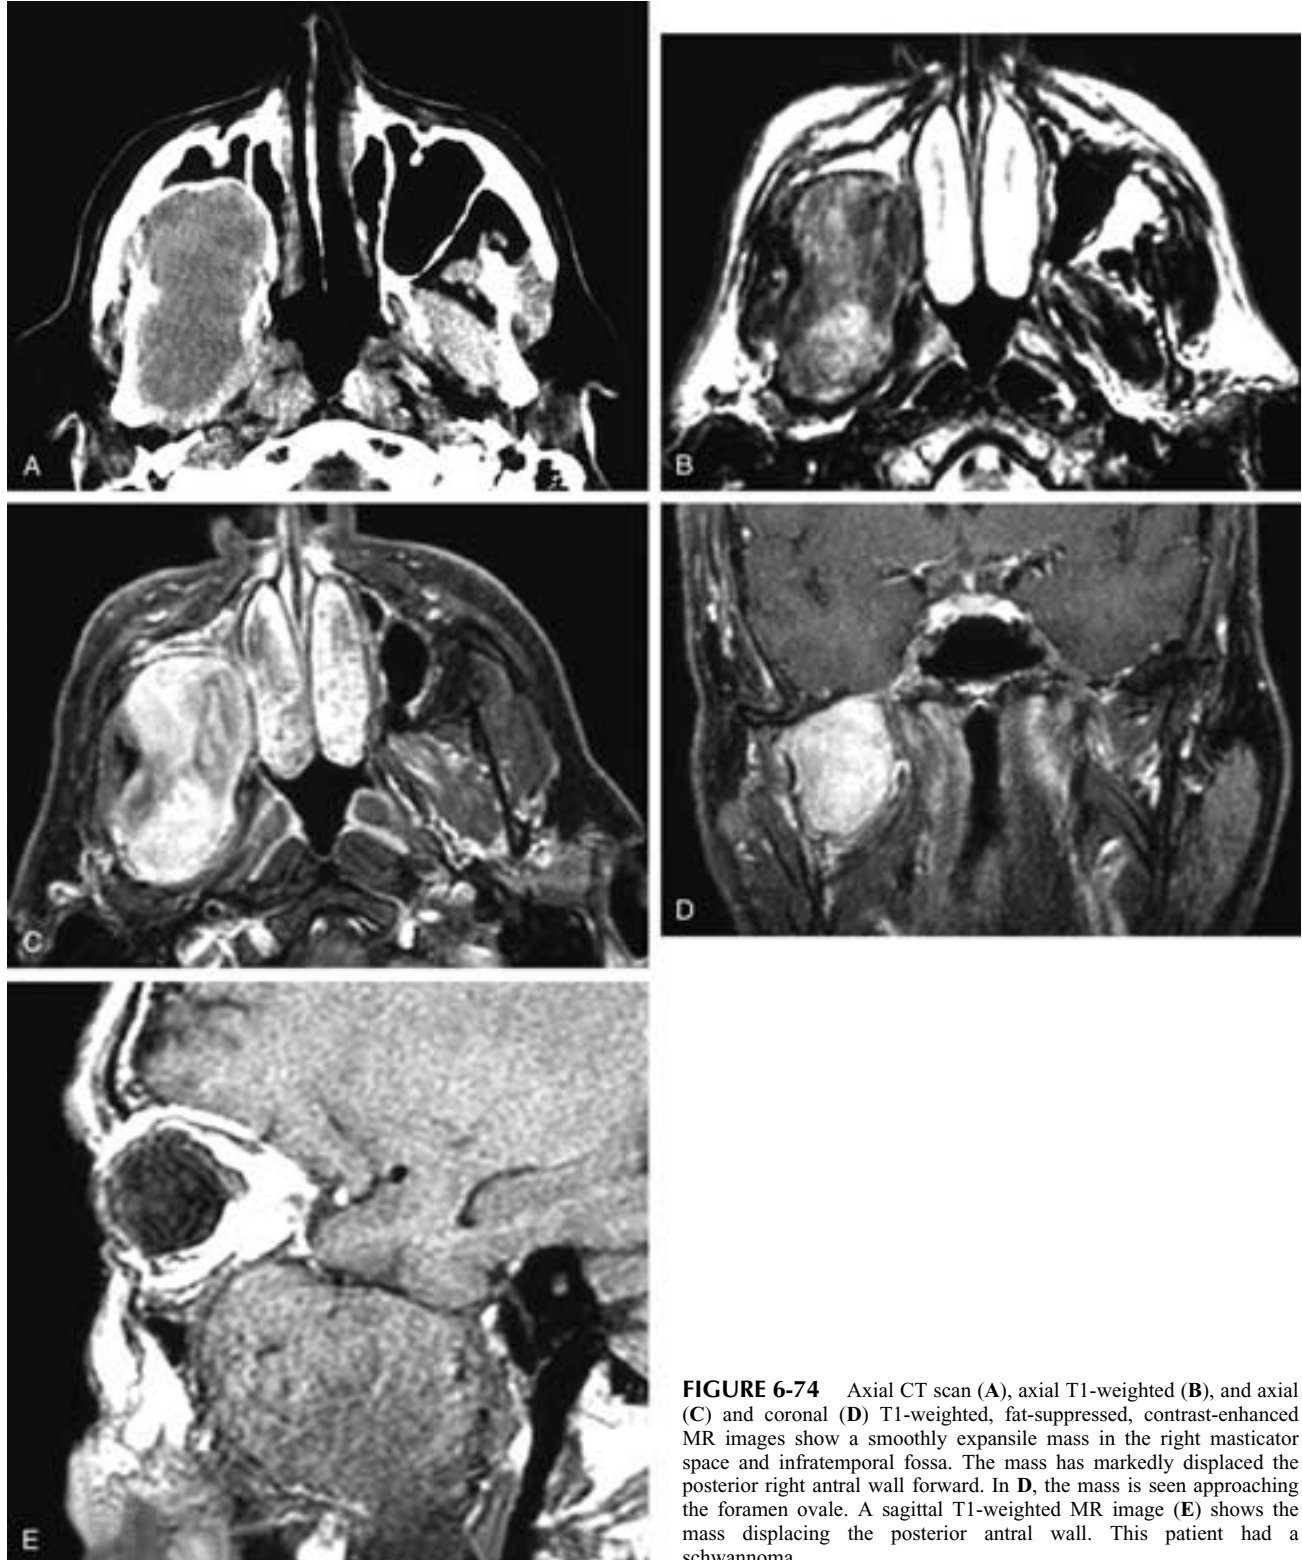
Axial CT scan (A), axial T1-weighted (B), and axial (C) and coronal (D) T1-weighted, fat-suppressed, contrast-enhanced MR images show a smoothly expansile mass in the right masticator space and infratemporal fossa. The mass has markedly displaced the posterior right antral wall forward. In D, the mass is seen approaching the foramen ovale. A sagittal T1-weighted MR image (E) shows the mass displacing the posterior antral wall. This patient had a schwannoma.
